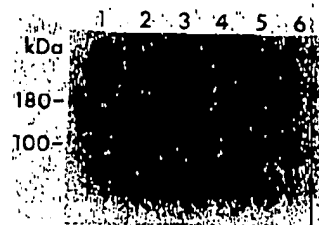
Detection of PSMA in non-prostate malignancies. Western blot analysis of 50 µg of membrane preparations from LNCaP cells (lane 1), colon (lane 2), lung (lane 3), bladder (lane 4), liver (lane 5) and breast adenocarcinoma (lane 6) showing the typical 100 and 180 kDa bands in the LNCaP cells but no expression in other malignant tissues.
